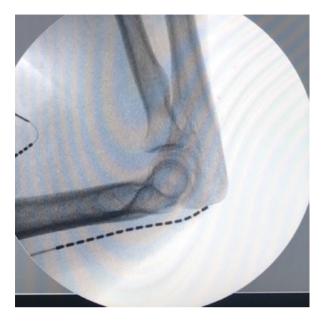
Radiographic confirmation from the electrode over the ulnar nerve
